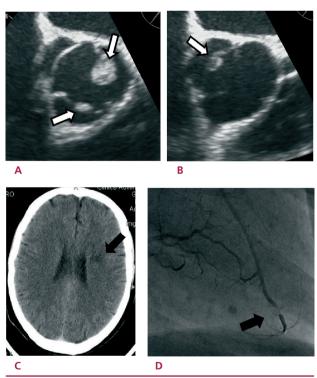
A and B. Preoperative short-axis images obtained with two-dimensional transesophageal echocardiography, showing a mobile mass attached to the left coronary cusp of the aortic valve and two additional masses attached to the right coronary cusp and non-coronary cusp, respectively. C. Preoperative computed tomography scan of the brain showing an ischemic focal lesion (arrow). D. Preoperative coronary angiography with a distal stenosis of the left anterior descending coronary artery (arrow), probably due to embolism.
